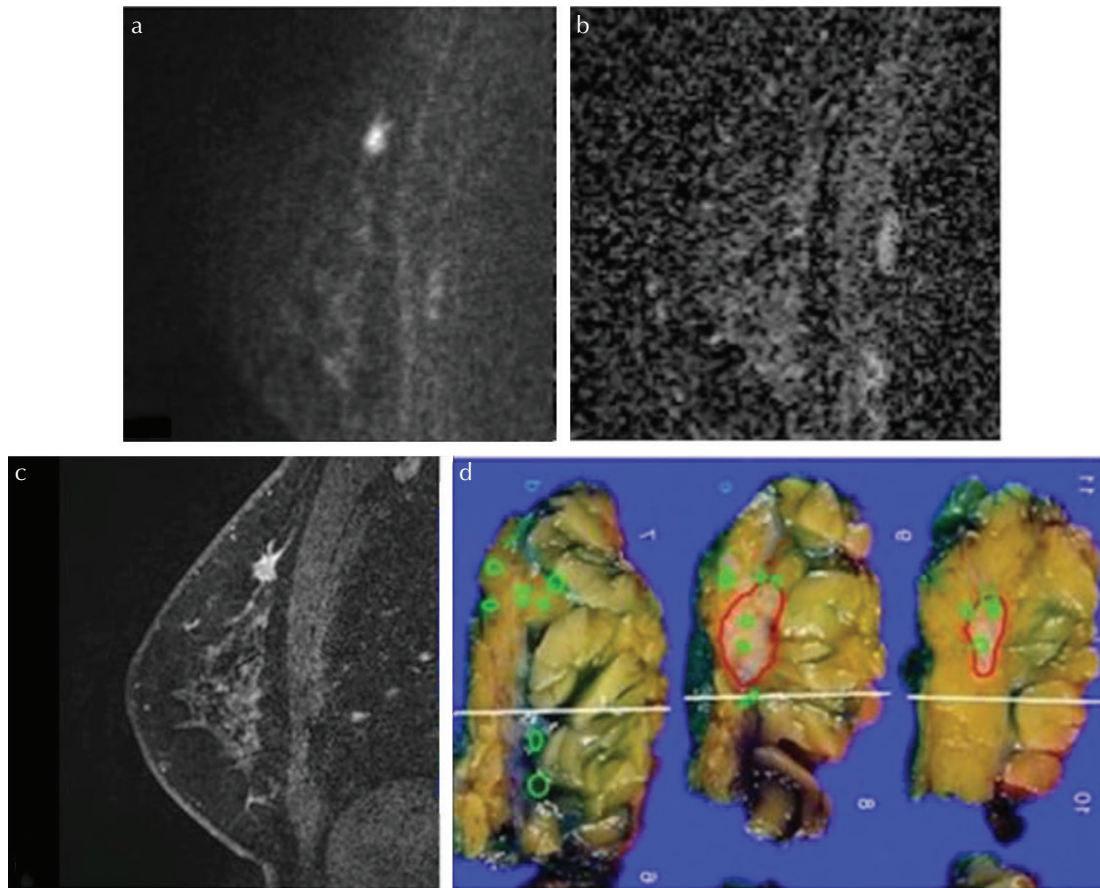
Malignant non-mass lesions in a 53-year-old patient. (a) A lesion with high signal intensity on HR-DWI ( $b = 850 \text{ s/mm}^2$ ) was detected. Both readers classified it as a non-mass lesion and reader A measured it as 40 mm and reader B measured it as 42 mm. (b) The lesion showed low ADC value. The mean ADC value of the lesion was  $0.779 \times 10^{-3} \text{ mm}^2/\text{s}$ . (c) High-resolution contrast-enhanced  $T_1$ WI showed a non-mass lesion with segmental distribution and clustered ring-pattern enhancement. (d) The diagnosis was high grade DCIS with invasion, and the depth of invasion was 2 mm. The pathological maximum diameter of the lesion was 50 mm. Lesions outlined in blue correspond to invasive carcinoma (NST) and those outlined in pink correspond to DCIS of high nuclear grade. ADC, apparent diffusion coefficient; DCIS, ductal carcinomas in situ; HR-DWI, high resolution-diffusion-weighted imaging; NST, no special type; T1WI, T1-weighted image.
